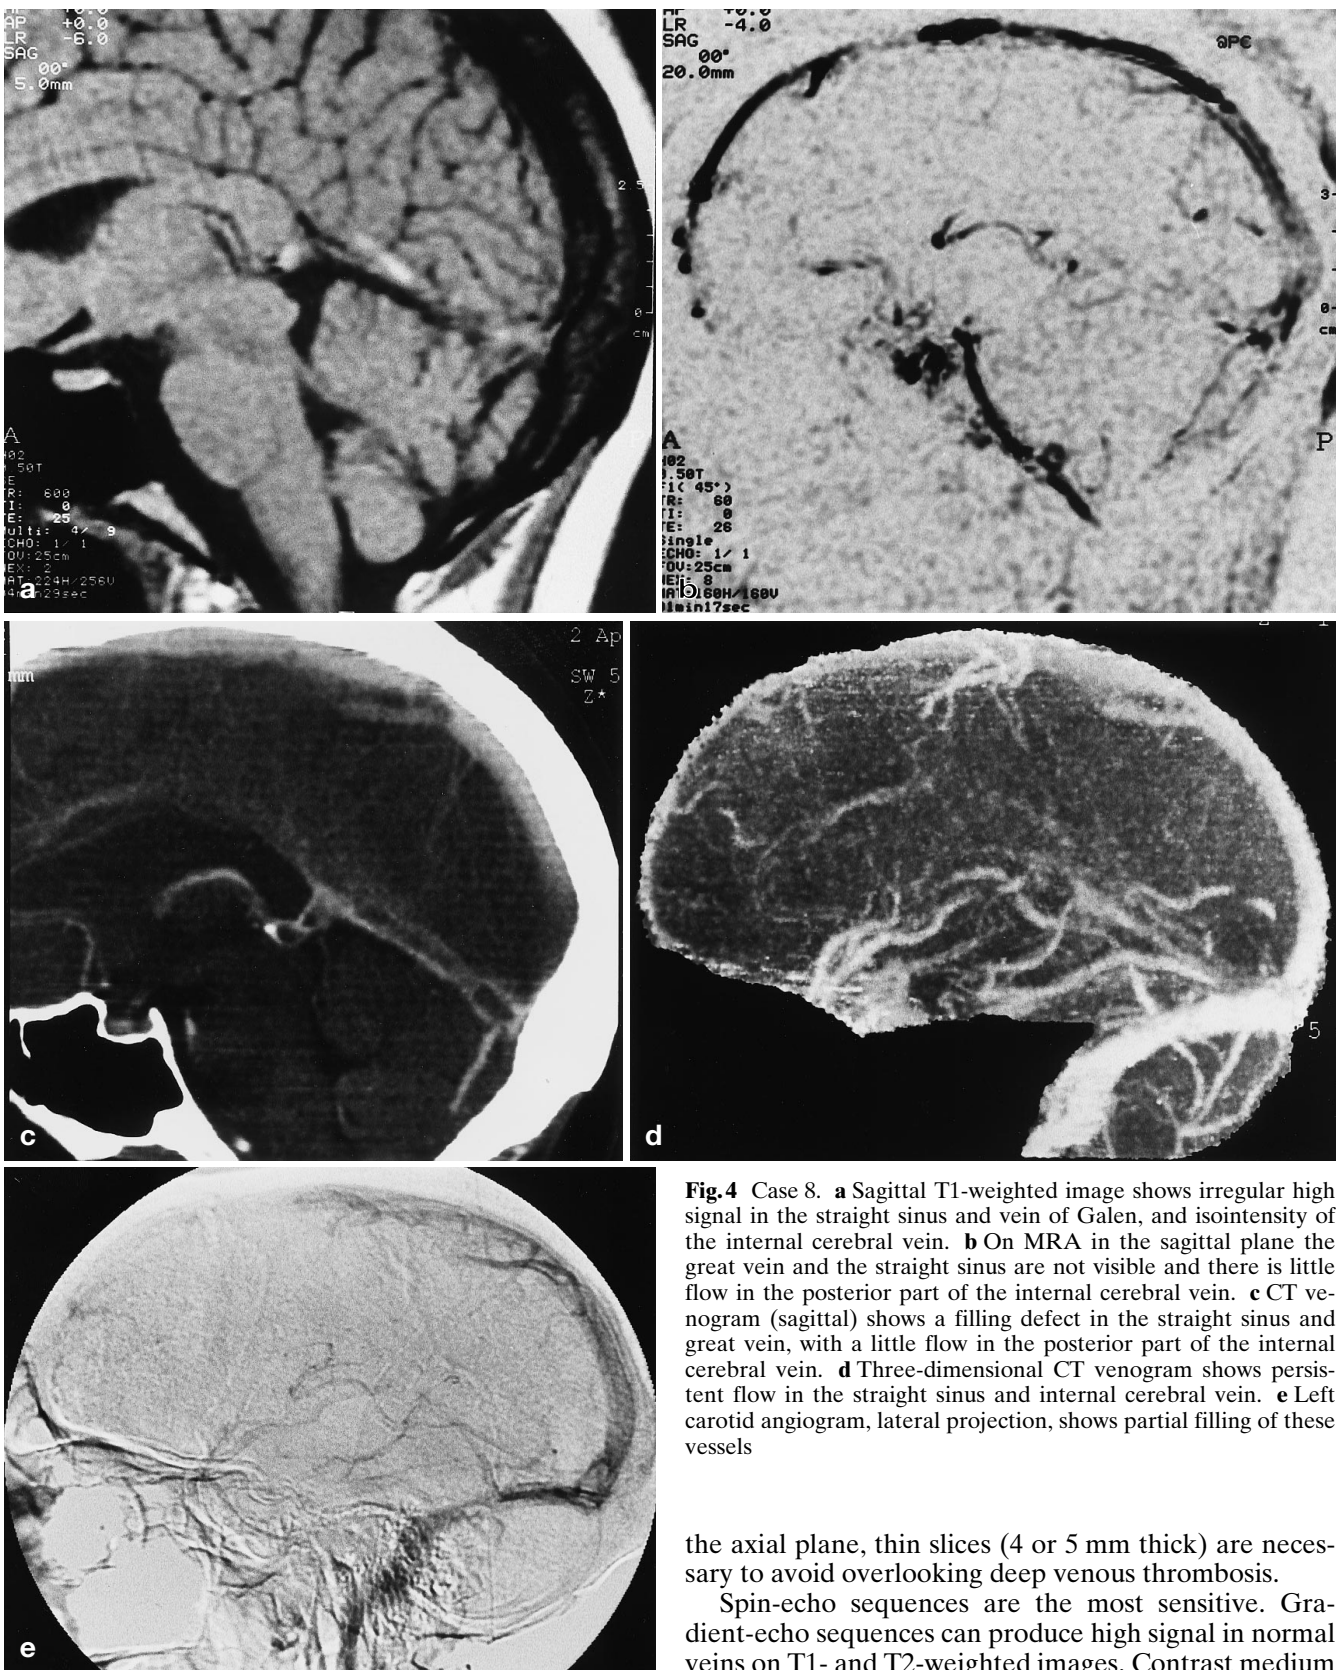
Case 8. a Sagittal T1-weighted image shows irregular high signal in the straight sinus and vein of Galen, and isointensity of the internal cerebral vein. b On MRA in the sagittal plane the great vein and the straight sinus are not visible and there is little flow in the posterior part of the internal cerebral vein. c CT venogram (sagittal) shows a filling defect in the straight sinus and great vein, with a little flow in the posterior part of the internal cerebral vein. d Three-dimensional CT venogram shows persistent flow in the straight sinus and internal cerebral vein. e Left carotid angiogram, lateral projection, shows partial filling of these vessels
